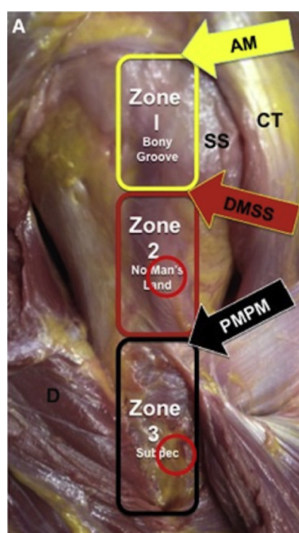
Visual depiction of biceps-labral complex with zone 2 red circle as site for arthroscopic suprapectoral tenodesis and zone 3 red circle as open subpectoral tenodesis location from Forsythe *et al* [120]. Citation: Forsythe B, Zuke WA, Agarwalla A, Puzitiello RN, Garcia GH, Cvetanovich GL, Yanke AB, Verma NN, Romeo AA. Arthroscopic Suprapectoral and Open Subpectoral Biceps Tenodeses Produce Similar Outcomes: A Randomized Prospective Analysis. *Arthroscopy* 2020; 36: 23-32. Copyright© The Authors 2020. Published by Elsevier. The authors have obtained the permission for figure (Supplementary material). AM: Articular margin; CT: Conjoined tendon; d: Deltoid; DMSS: Distal margin of subscapularis tendon; PMPM: Proximal margin of pectoralis major; SS: Subscapularis.
